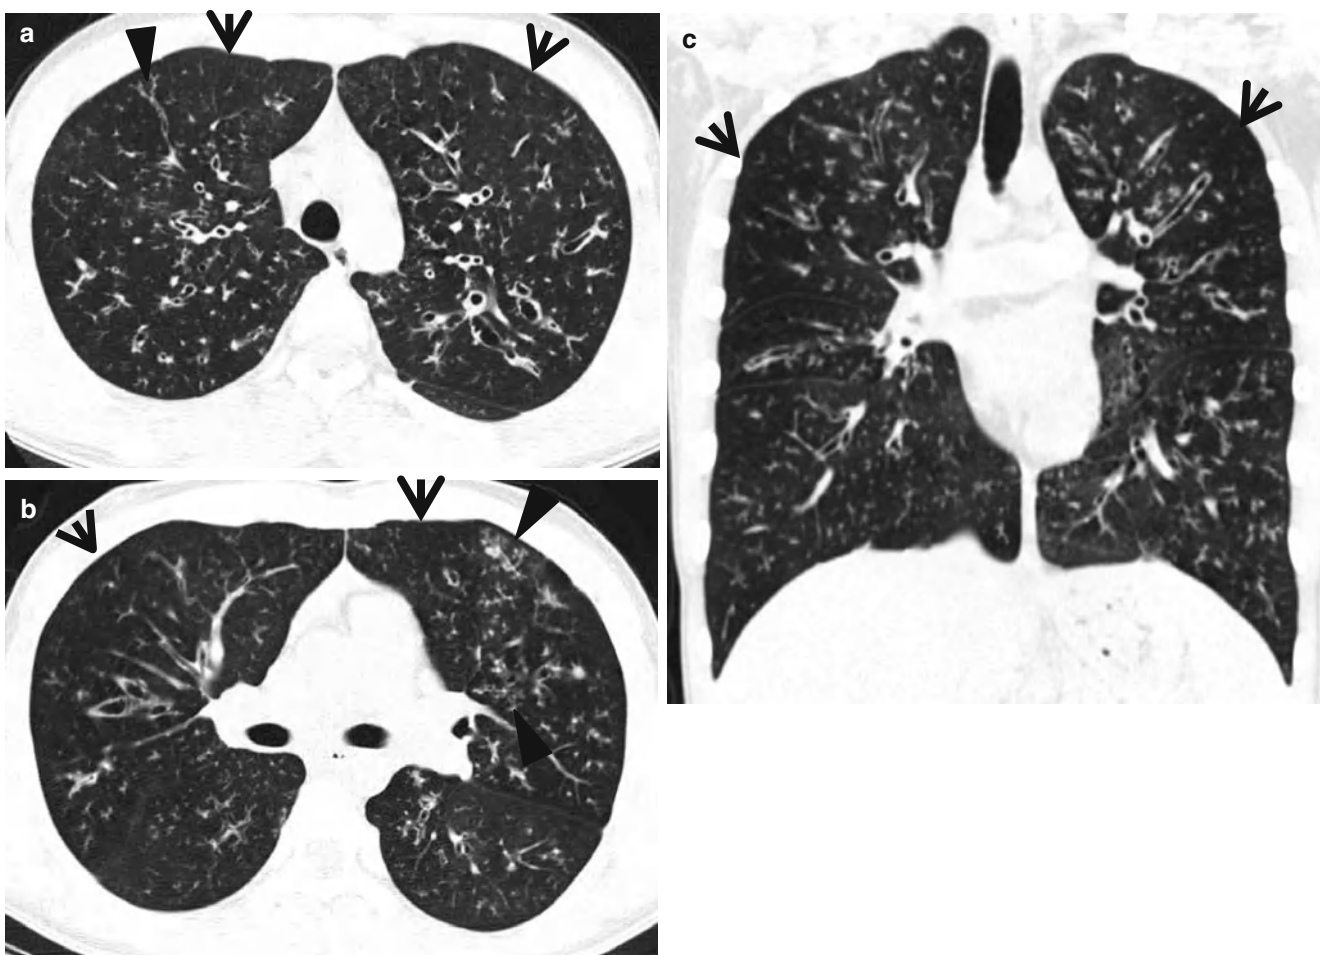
Cystic fibrosis in a 24-year-old man who underwent lung transplantation. (a, b) Lung window images of thin-section (2.5-mm section thickness) CT scans obtained at levels of aortic arch (a) and main bronchi (b), respectively, show extensive areas of bronchiectasis and cellular bronchiolitis (arrowheads) in both lungs. Also note bilateral patchy areas of mosaic attenuation (arrows). (c) Coronal reformat CT image (2.0-mm section thickness) demonstrates bronchiectasis
